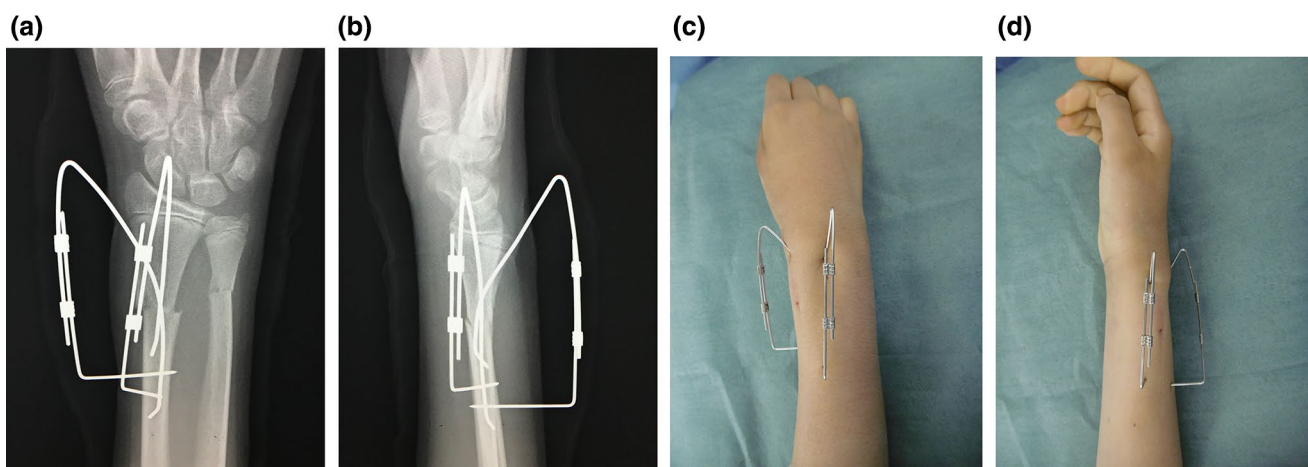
Postoperative plain radiography and locked wires fixator. Both the radius and ulna were reduced. In the radius, the K-wire intramedullary nail inserted from the radial dorsal side and mini fixator pin
